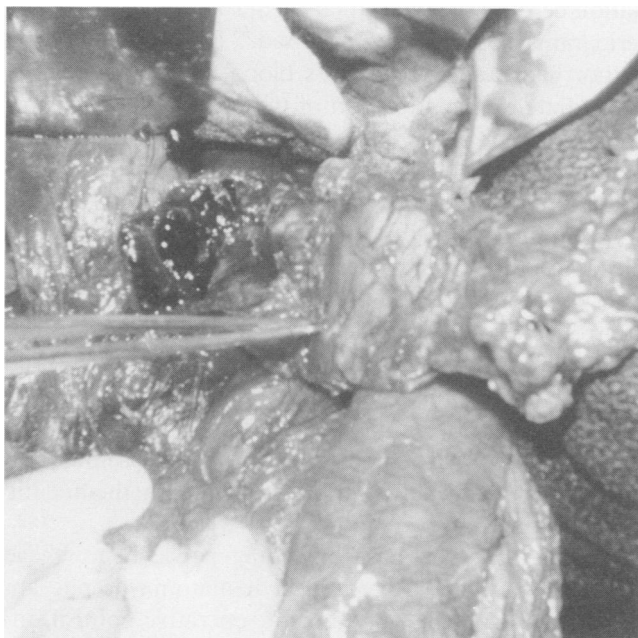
Transection of the pancreas discovered when the hematoma seen in Figure 7 was opened. (From Feliciano DV. In Schwartz SI, Ellis H, eds. *Maingot's Abdominal Operations*, 9th ed. East Norwalk, CT: Appleton & Lange, 1989; publication pending. Reprinted with permission.)
